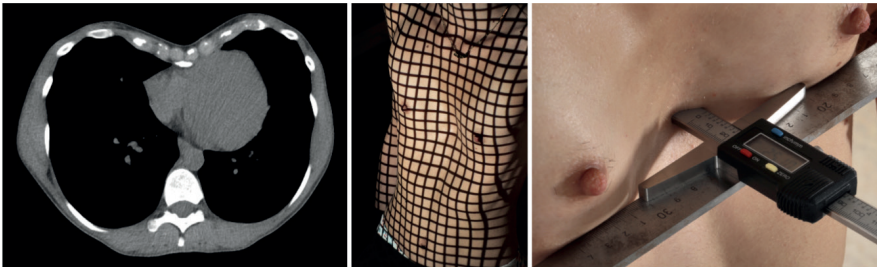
Patient D. Preoperative CT, 3D grid stereogram and digital measurement of external pectus depth.
